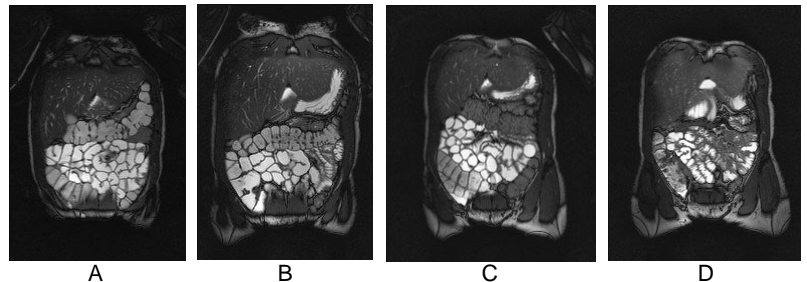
MRI of the small bowel after the administration of 1350ml of oral contrast agents. (A) 0.2% locus bean gum combined with 2.5% mannitol, (B) 2.0% sorbitol, (C) 1.4% sorbitol and (D) tap water
